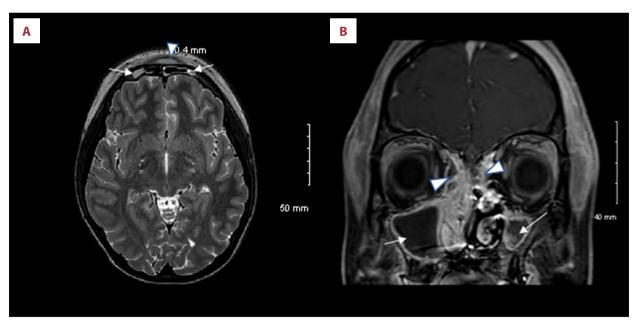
(A). Orbit and brain MRI with contrast shows 5×0.8×4 cm of frontal scalp subgaleal rime enhancing fluid collection, showing subgaleal abscess (arrow head) with mild restricted diffusion within the frontal calvarium, compatible with early changes of osteomyelitis. Moderate fluid collection is shown in underlying frontal sinuses (arrows). (B) MRI brain and orbit shows fluid throughout maxillary sinuses, with mild mucosal thickening bilaterally (arrows). Fluid and mucosal thickening within ethmoid air cells is shown (arrow heads). The findings show acute and chronic sinusitis.
